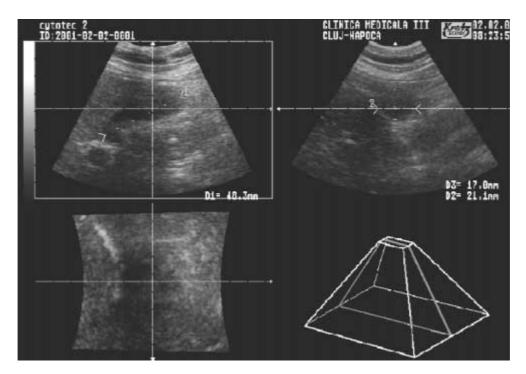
Gallbladder volume assessment after the 3D ultrasound reconstruction of the gallbladder
